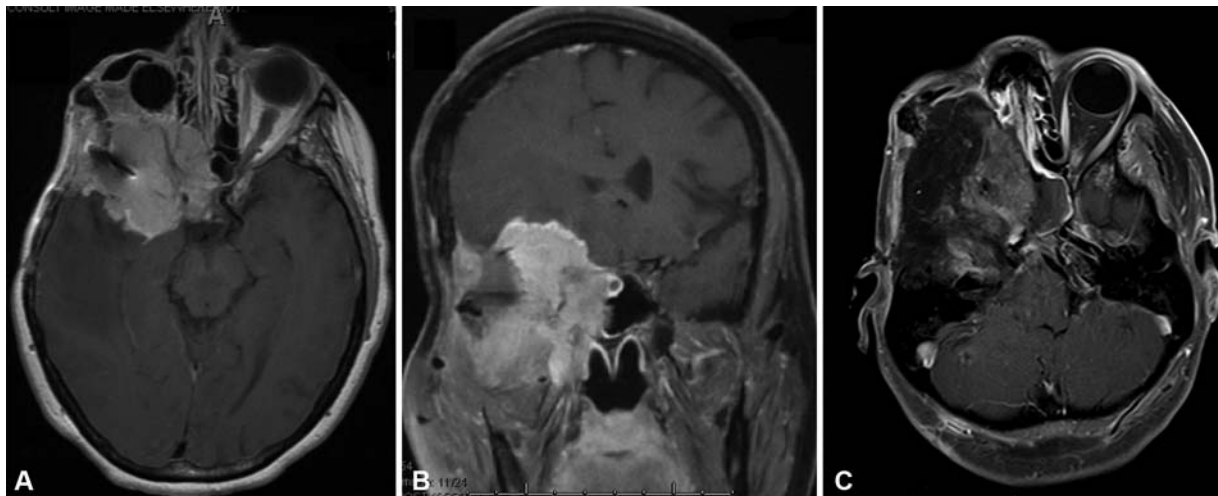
Extensive recurrent orbital and cavernous sinus meningioma. This 42-year-old woman had a long history of subtotal resection and recurrent orbital and cavernous sinus meningioma. She had undergone ocular resection with placement of prosthesis, with evidence of extensive recurrence within the orbit and right cavernous sinus (A, axial and B, coronal postcontrast, T1-weighted magnetic resonance imaging [MRI]). Cavernous sinus resection was performed with exenteration of the orbital contents and removal of the right cavernous sinus and cavernous internal carotid artery. Postoperative axial (C, postoperative axial postcontrast, T1-weighted MRI) image demonstrates a complete resection, with placement of a thigh free flap.
